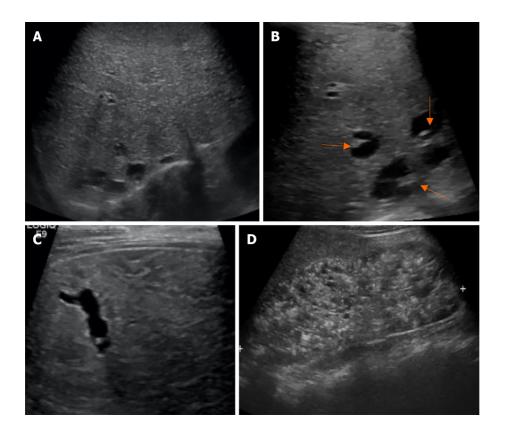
A 32-wk-old female infant with a family history of consanguinity, presented with an abdominal mass. She was diagnosed with Calori syndrome (congenital hepatic fibrosis, choledochal cyst type V, and multiple cysts in the kidneys). Abdominal ultrasonography revealed enlargement of the left hepatic lobe, coarse parenchymal echotexture with a periportal hyperechoic band, small cysts in a posterosuperior segment of the right hepatic lobe, and marked enlargement of both kidneys with evidence suggestive of multi-cystic kidney disease. She had upper gastrointestinal bleeding from esophageal varices that can be controlled with esophageal ligation at the 8-year follow-up. A: Diffusely enlarged liver and coarse parenchymal echogenicity with several round and tubular cystic-like structures; B: Focal intrahepatic dilatation with central dot sign; C: Tubular cystic-like structures; D: Markedly enlarged kidneys with loss of corticomedullary differentiation, and multiple cysts in the medulla and cortices.
